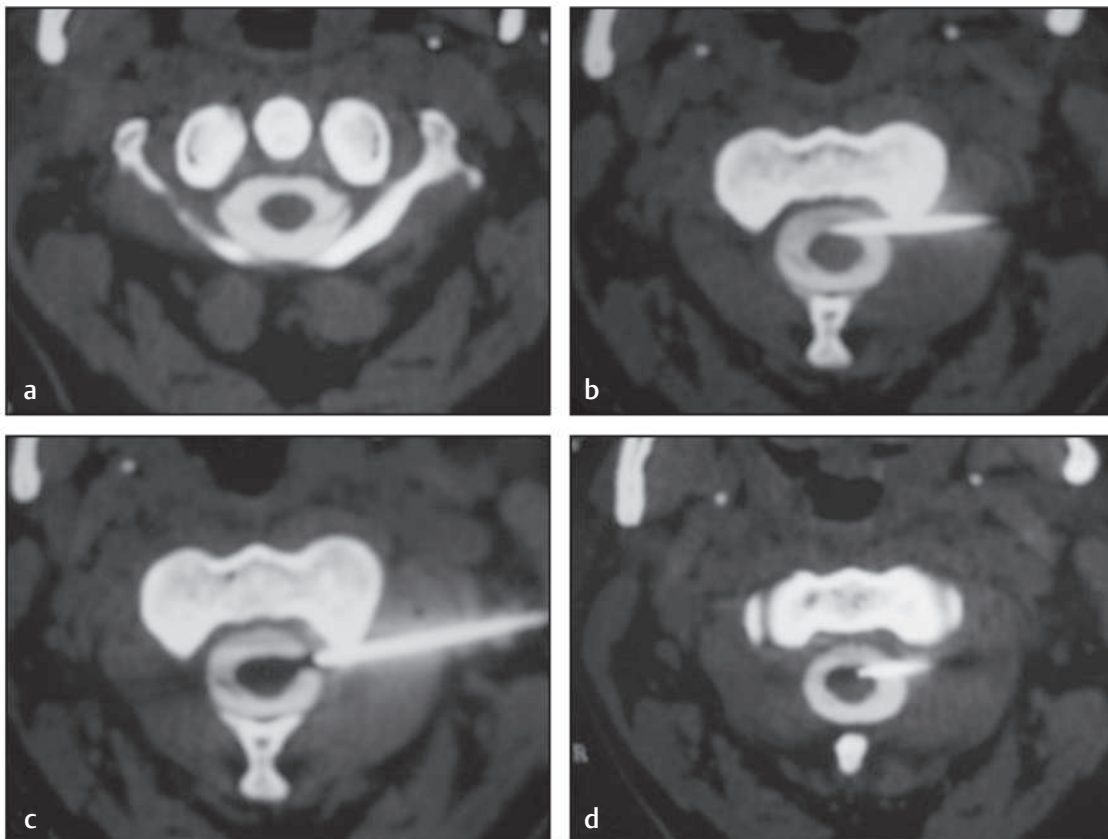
(a) CT (computed tomography) myelography revealing the dentate ligament and the upper cervical spinal cord; the cord diameter and skin dura thickness are obtained from the image. (b) The needle introduced to a trajectory anterior to the cord. (c) The needle trajectory is adjusted to proper targeting of the anterolateral quadrant. (d) The electrode is inserted through the needle into the spinal cord.
